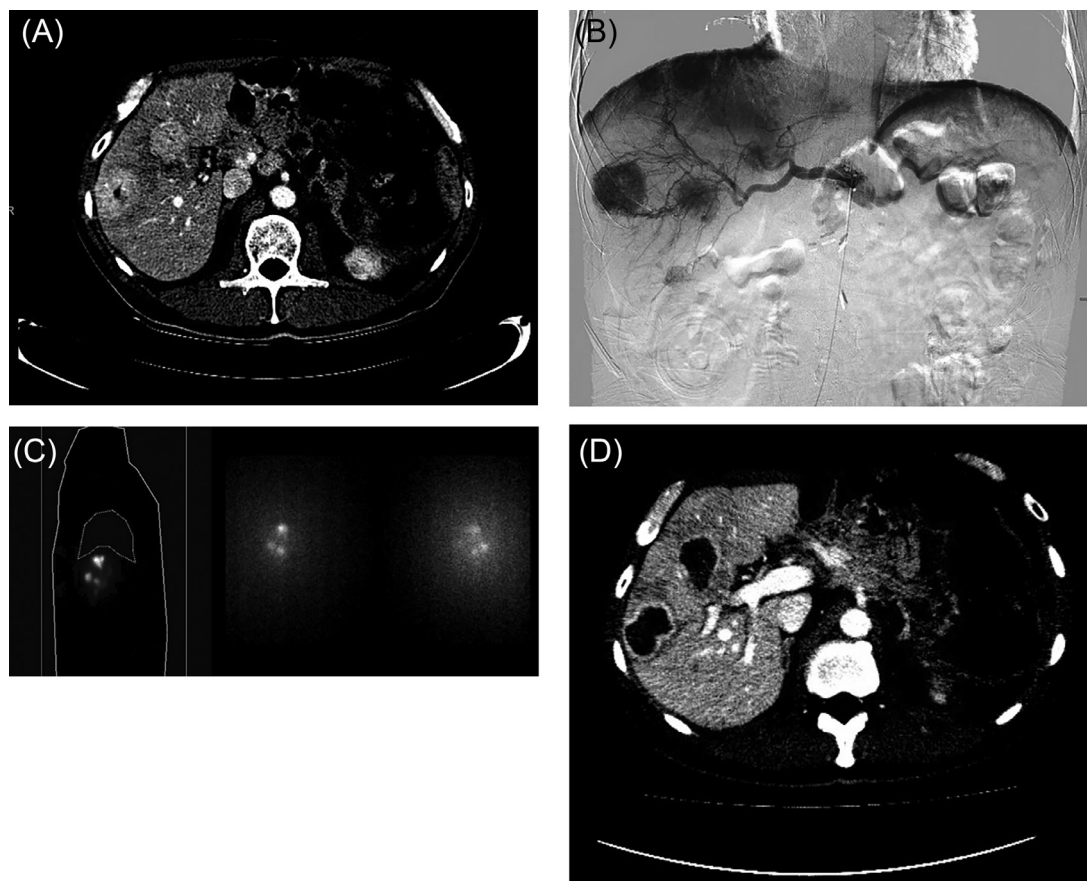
A 68-year-old male post pancreatic resection of high grade neuroendocrine tumor presents with multifocal hepatic metastatic disease that progressed after bland embolization (A). Mapping celiac angiography demonstrates a strong arterial flow preferential to lesions with robust microvascular conduit. Macrovascular conduit is only mildly limited by extrahepatic disease encasing the common hepatic artery origin.* (B) Planar post-Tc-MAA and (C) post-TARE Bremsstrahlung planar scintigraphy confirm the intrinsic tumor dose preferential rendered by its arterial supply (D) A 1-month CT demonstrates mRECIST complete response in all hepatic lesions.
